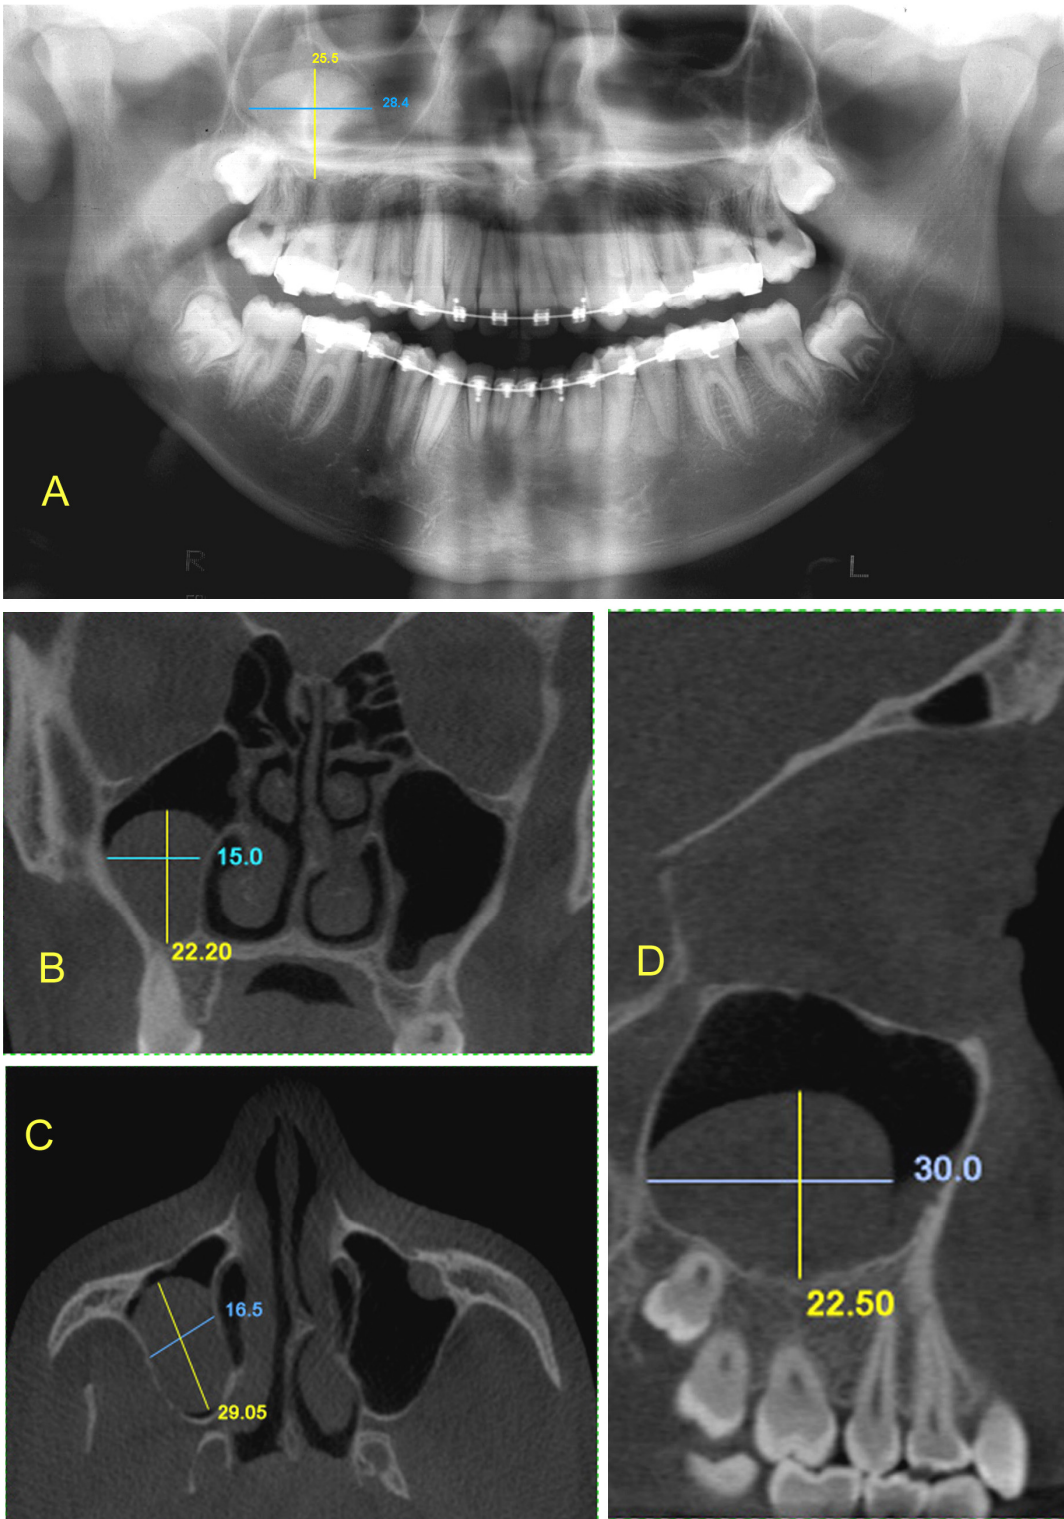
Measurement of MRCMS in panoramic radiograph (A) and in CBCT images in in coronal (B), axial (C) and sagittal (D) reconstructions.
